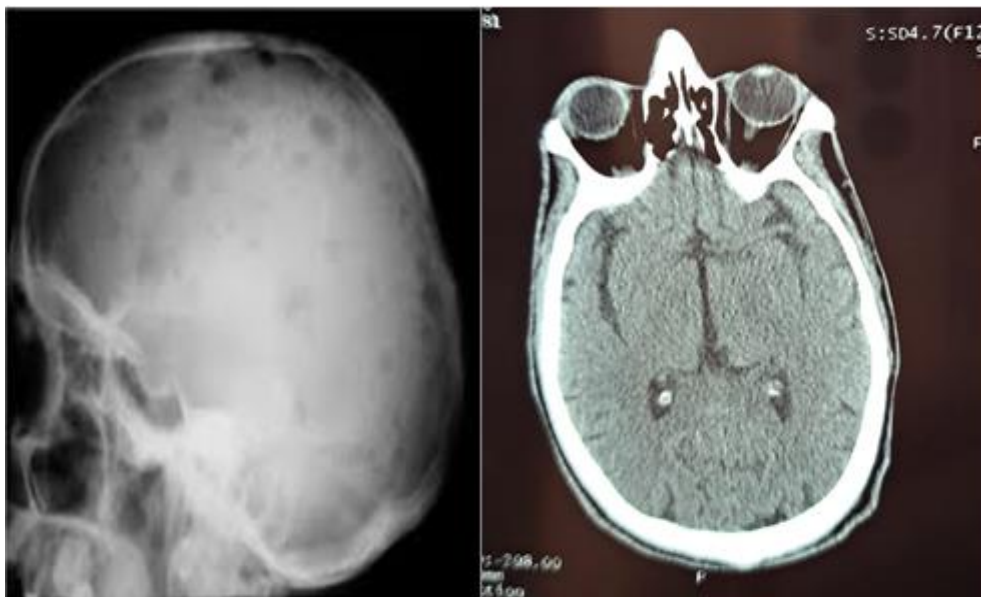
Cranial X-Ray + Cerebral CT Scan
